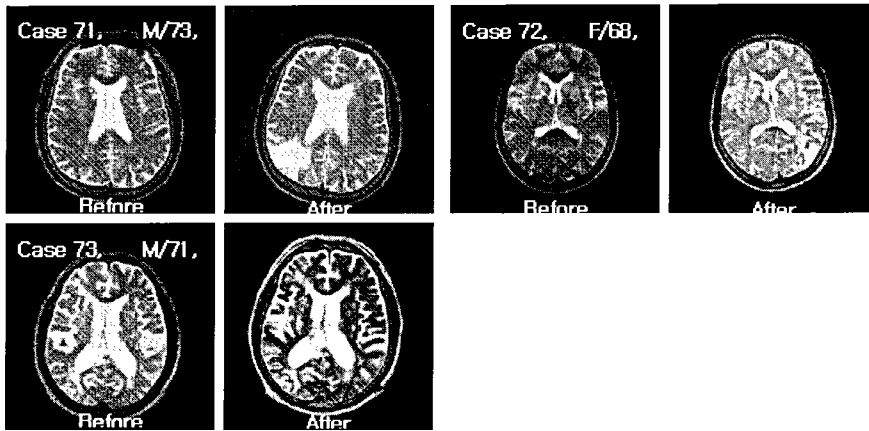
Brain MRI before and after 1 year of *Chunghyul-dan* medication in Cases 71 to 73. New vascular events were found in these three cases: Case 71 had a new lesion at the right parietal lobe; Case 72 had a new ischemic infarction at the left occipitoparietal lobe; and Case 73 had acute to subacute focal infarction at the right basal ganglia.
